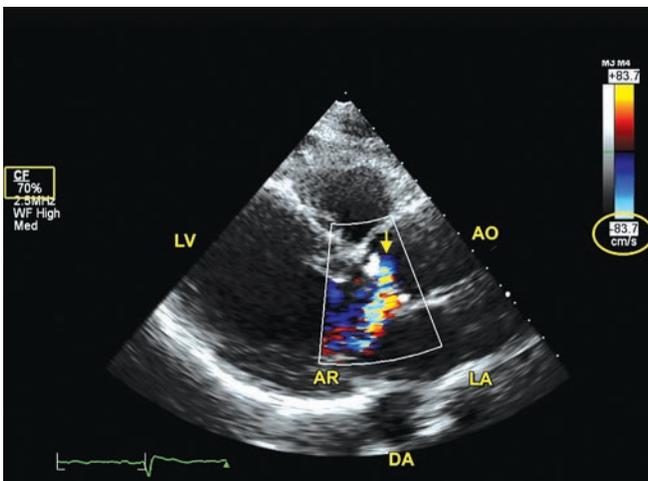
Parasternal long axis view showing eccentric AR.
